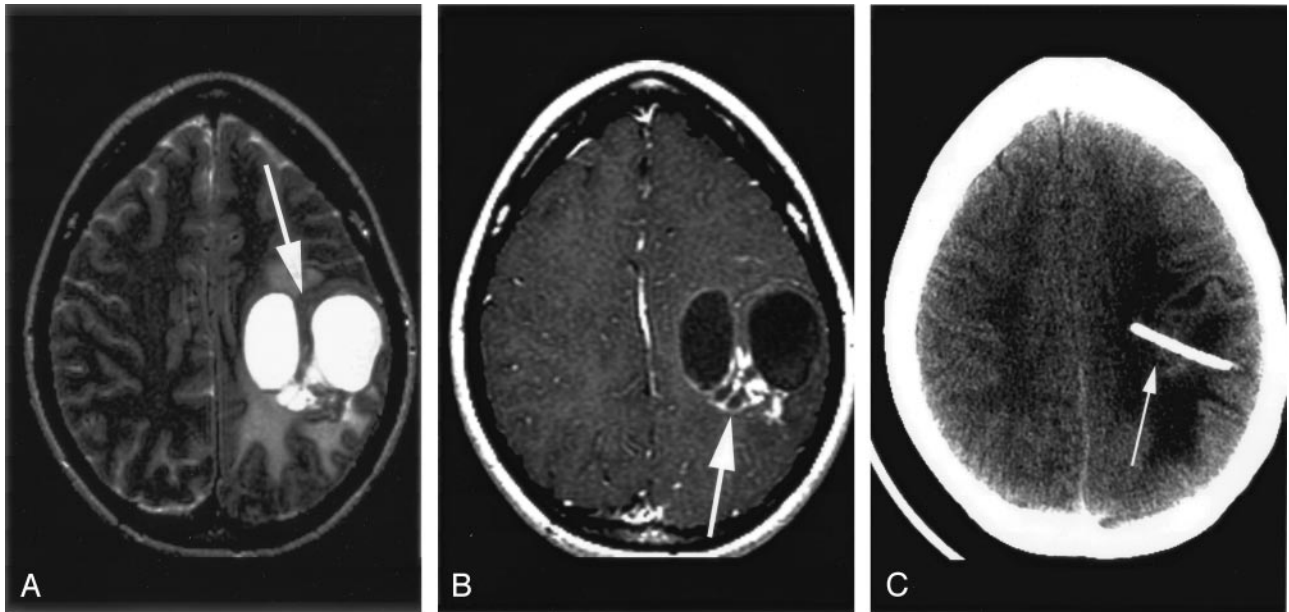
MR image obtained 40 months after AVM ablation.
